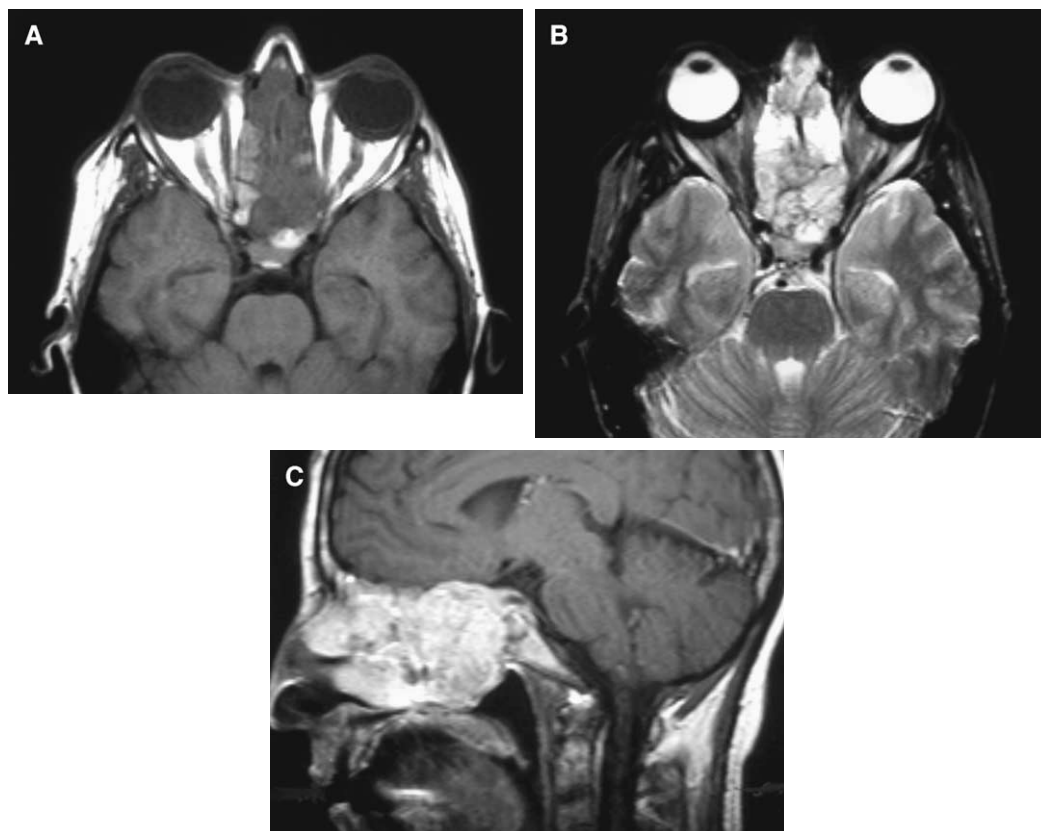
Chondrosarcoma. (A) Axial T1-weighted image shows a mixed signal intensity mass involving the sphenoid and ethmoid sinuses. (B) Axial T2-weighted image shows a heterogeneous hyperintense mass. (C) Sagittal postcontrast T1-weighted image demonstrates a heterogeneous enhancing mass involving the sphenoid and ethmoid sinuses, with extension into the nasal cavity.
